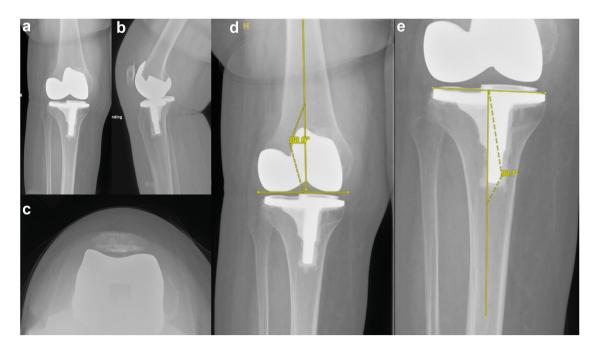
Right total knee arthroplasty postoperative radiographs with axis measurements.
